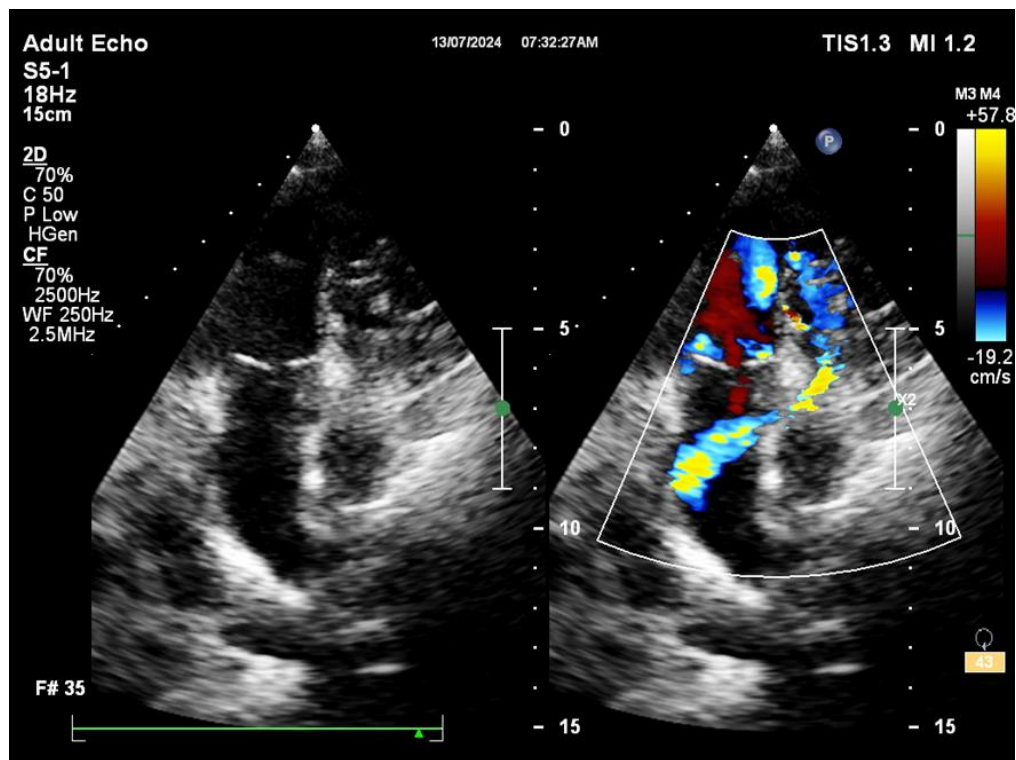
Transthoracic echocardiography showing blood flow draining towards pulmonary artery
